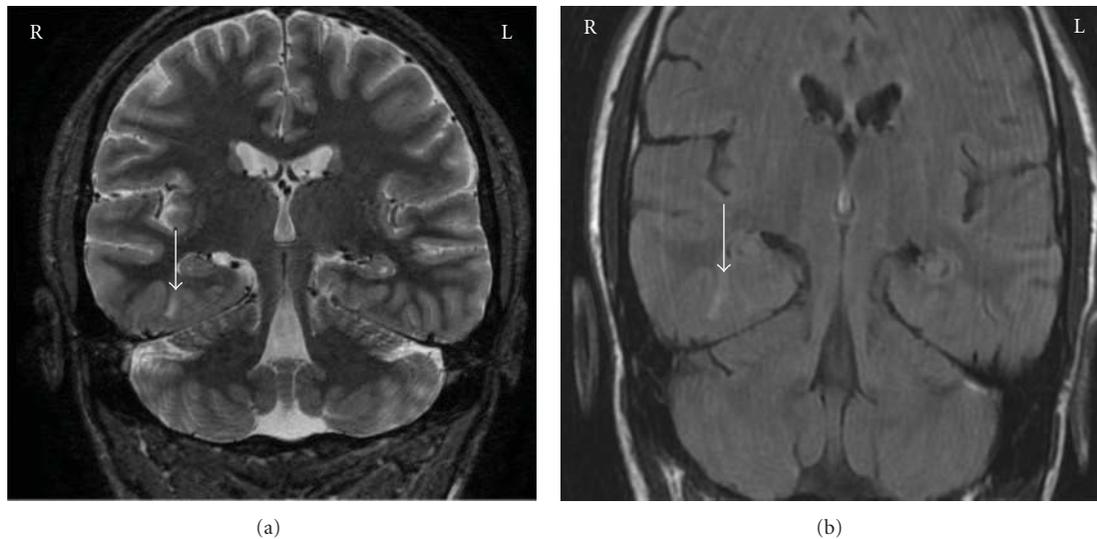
Mr. C—T2-weighted and FSTIR sequence MR demonstrating a right inferior temporal lobe lesion in addition to left MTS.
